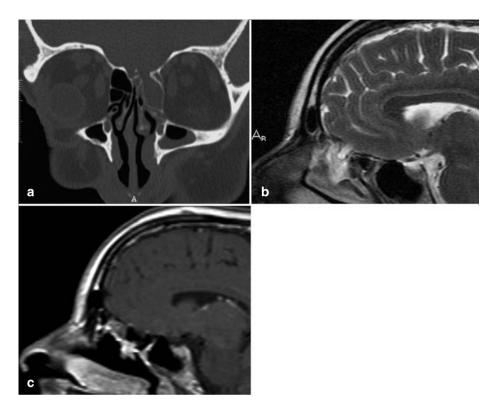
Pre-operative neuroradiological studies showing a left ethmoidal meningoencephalocele. a) Coronal CT scan and b) sagittal MRI. c) Post-operative sagittal MRI, showing the complete removal of the meningoencephalocele and presence of reconstruction material in the anterior ethmoid
